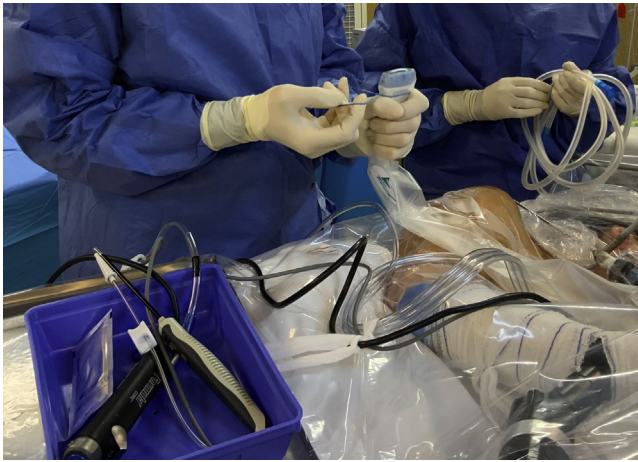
Right shoulder in a 52-year-old female patient in lateral position ultrasound probe covering with sterile sleeve.
